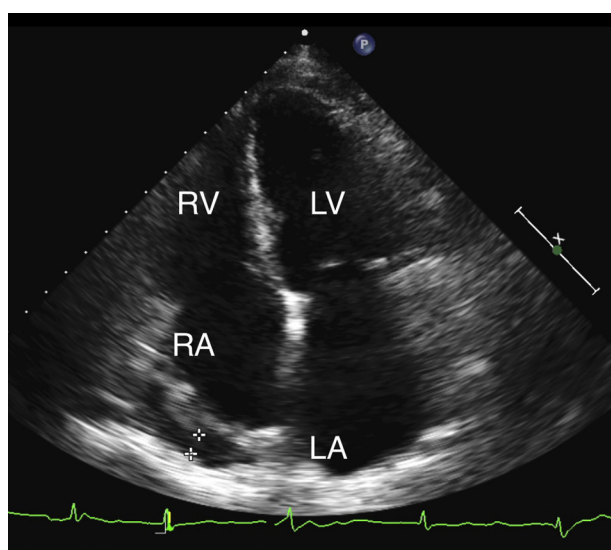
Transthoracic apical four-chamber view from postoperative echocardiography confirming the expected absence of left atrial mass lesions. A small pericardial fluid collection is seen posterior to the right atrium (RA). LA, Left atrium; LV, left ventricle; RV, right ventricle.
